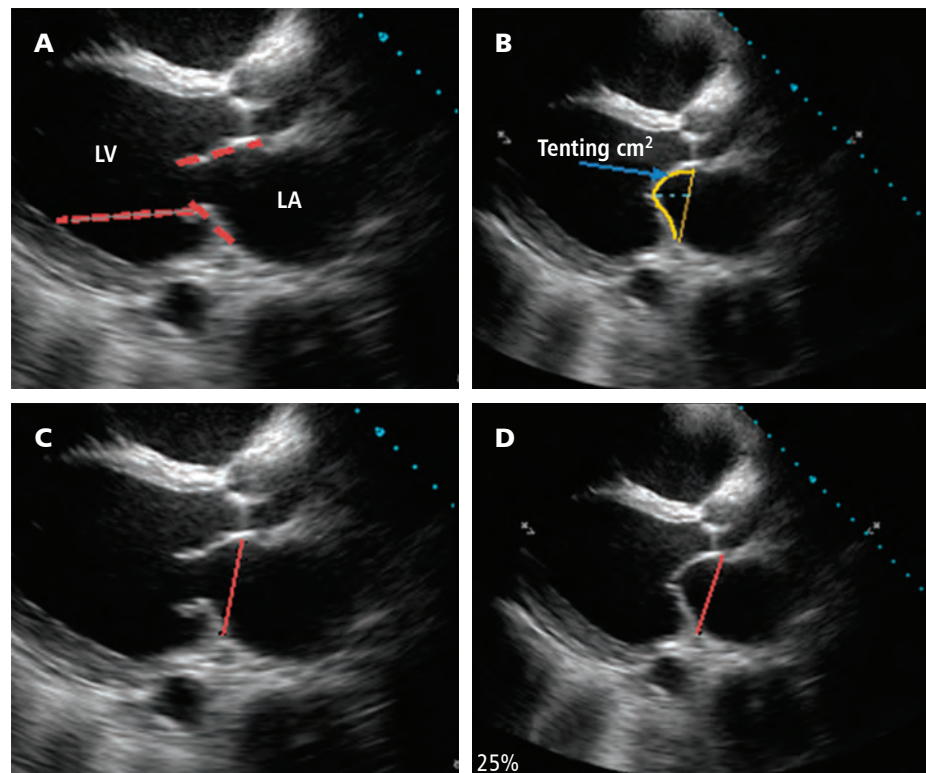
Evaluation by echocardiography 2D of ischemic mitral regurgitation. Long parasternal axis in a patient with inferior infarction and ischemic mitral regurgitation. A) Showing in diastole the longitudinal measurement of the anterior and posterior leaflets and chordae tendineae (from its union with the valve to the papillary muscle), dotted red line, the increase in the length of these structures denotes plasticity. B) Tenting is the area that borders the valve in the meso-systole (yellow line). The increase of it, denotes tethering of the valve; the dotted blue line shows the depth of coaptation going from the valve annulus to the coaptation site of both leaflets, both the tenting and the depth of coaptation denote the restrictive closure of the valve. C and D) Show how the annulus is measured in end-diastole (C) and early-systole (D), red line, it should normally shorten antero-posteriorly at least 25%. LV = left ventricle; LA = left atrium.
